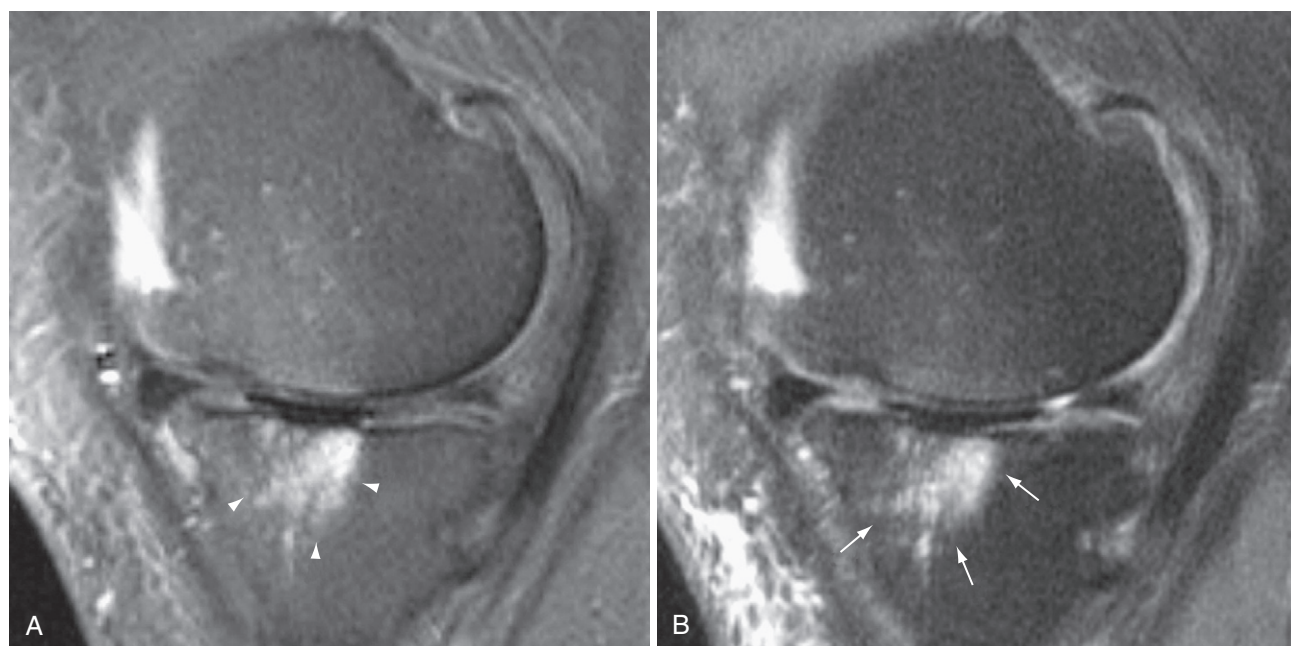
Subchondral bone marrow lesion (BML) in osteoarthritis. A, Sagittal proton density fat suppressed (FS) image. Tibial BML is depicted as diffuse hyperintensity (arrowheads). B, T1-weighted FS image after intravenous gadolinium diethylene triamine penta-acetic acid administration shows BML with similar extent (arrows). (From Roemer FW, Frobell R, Hunter DJ, et al: MRI-detected subchondral bone marrow signal alterations of the knee joint: terminology, imaging appearance, relevance and radiological differential diagnosis, *Osteoarthritis Cartil* 17:1115–1131, 2009.)
